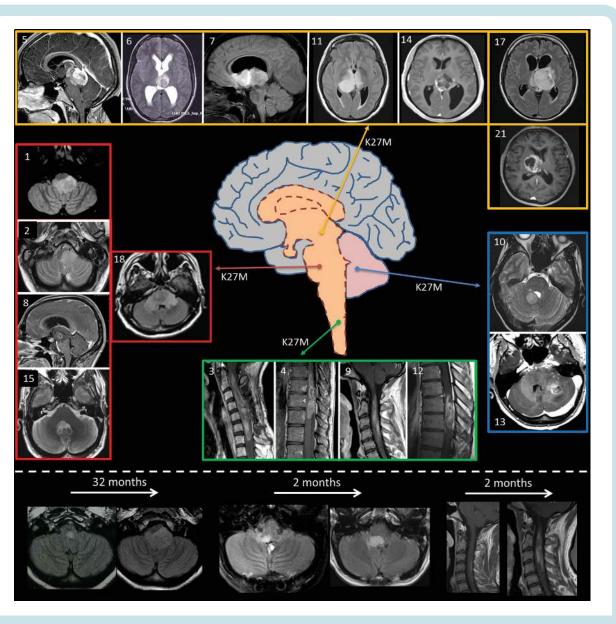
MRI characteristics of adults with H3 K27M-mutant gliomas. Top: numbers correspond to the patient numbers. For patients 1, 2, 6, 7, 10, 11, 15, 17, and 18, who had non-enhancing tumor, axial T2/fluid-attenuated inversion recovery (FLAIR) sequences are shown. For patients 3, 4, 5, 8, 9, 12, 13, 14, and 21, who had contrast-enhancing tumor, T1 post-contrast sequences are shown. Bottom: tumor growth before treatment onset in patients 1, 15, and 9. Patient 1 presented with unexplained anorexia and vomiting 32 months before diagnosis that led to an MRI that was considered normal at the time despite the presence of a hypersignal within the medulla oblongata. In patient 15, initial suspicion of grade I ganglioglioma led to an initial follow-up. In patient 9, initial follow-up resulted from the initial suspicion of a myelitis.
